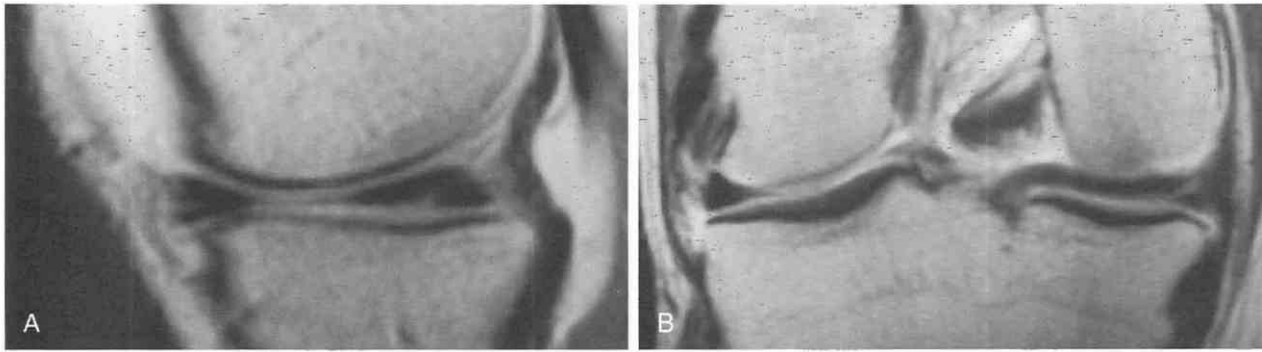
Sagittal (*A*) and coronal (*B*) T1-weighted images of the knee following the intra-articular injection of a gadolinium saline solution show contrast material within the posterior horn of the medial meniscus, after partial meniscectomy, indicative of a recurrent tear.
